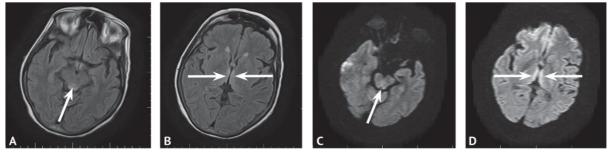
Magnetic resonance imaging of the brain of patient L. T2 FLAIR-images, axial sections: A — the arrow indicates the high signal area in the region of the quadrigeminal plate, specific for Wernicke encephalopathy; B — symmetric areas of increased signal from the medial parts of the thalamus; DWI-images, axial sections: C — the arrow indicates the area of hyperintensive signal from the quadrigeminal plate; D — arrows indicate the area of hyperintensive signal from the medial thalamus, specific for Wernicke encephalopathy
